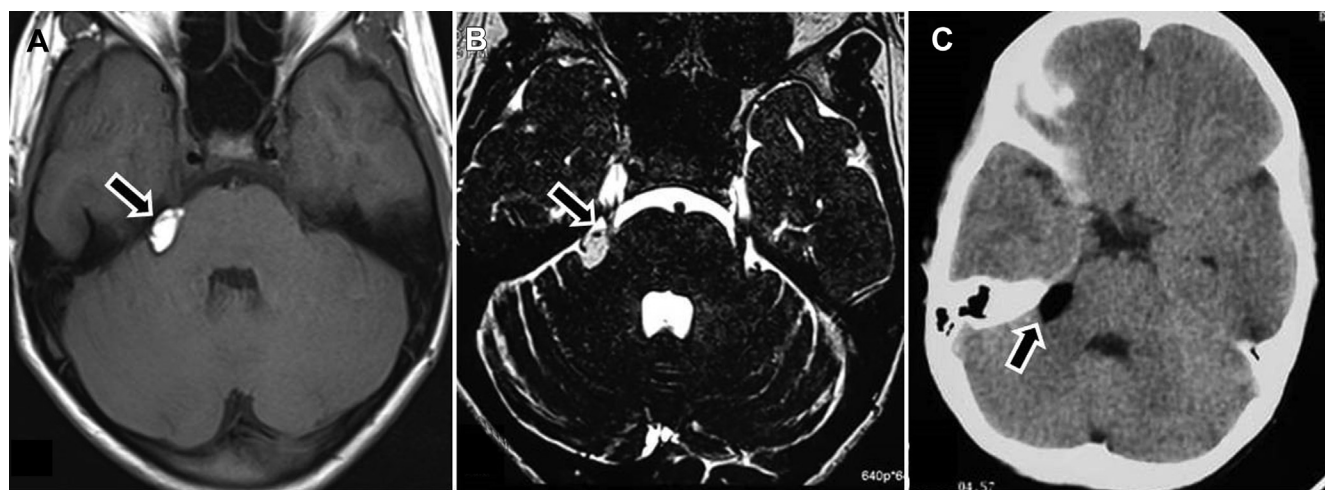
A, Axial T1-weighted magnetic resonance imaging of brain showing a well-defined hyperintense lesion in the right cerebellopontine angle (arrow). B, The lesion is causing indentation over the root entry zone of the right trigeminal nerve (arrow) and appears hyperintense on an axial fast imaging employing steady-state acquisition sequence. C, Axial noncontrast computed tomography scan showing fat attenuation of the lesion.
